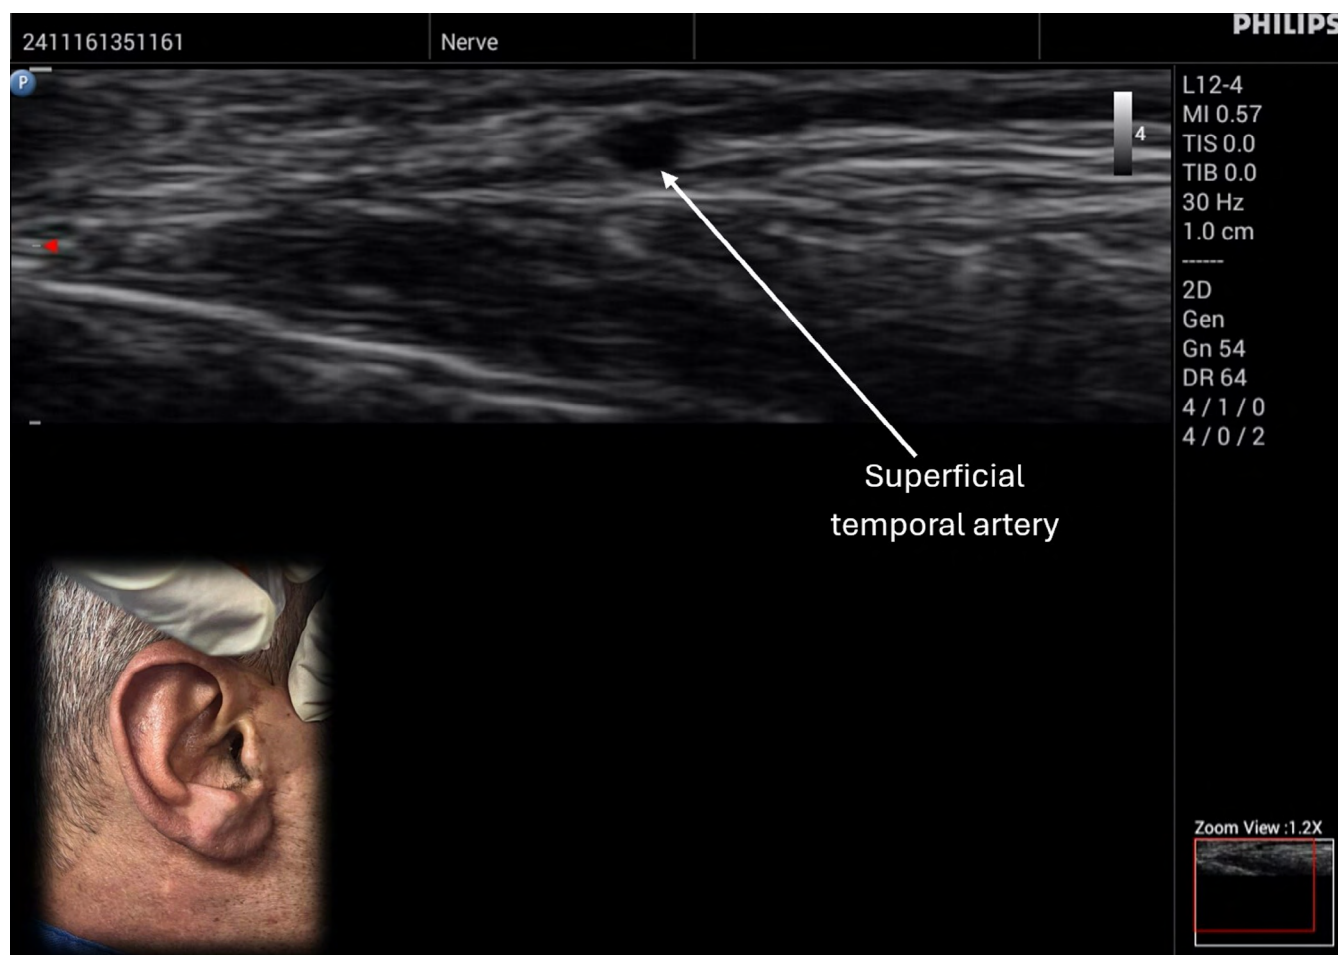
Sonographic vs anatomical landmark of superficial temporal nerve (STN) block.
